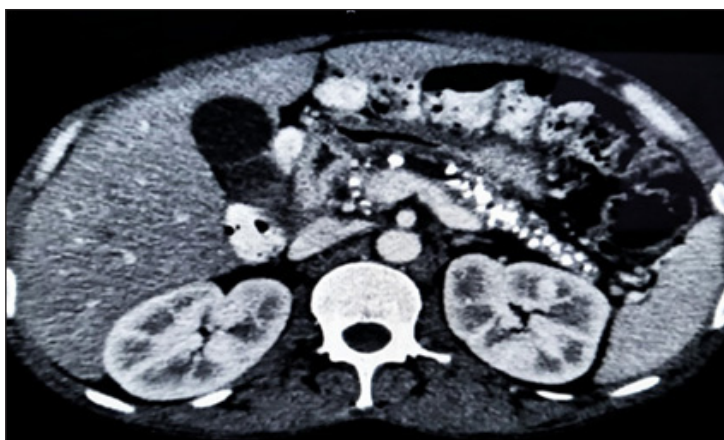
Contrast-enhancing computed tomography scan of abdomen showing multiple calcifications involving the head, body, and tail of the pancreatic parenchyma.
